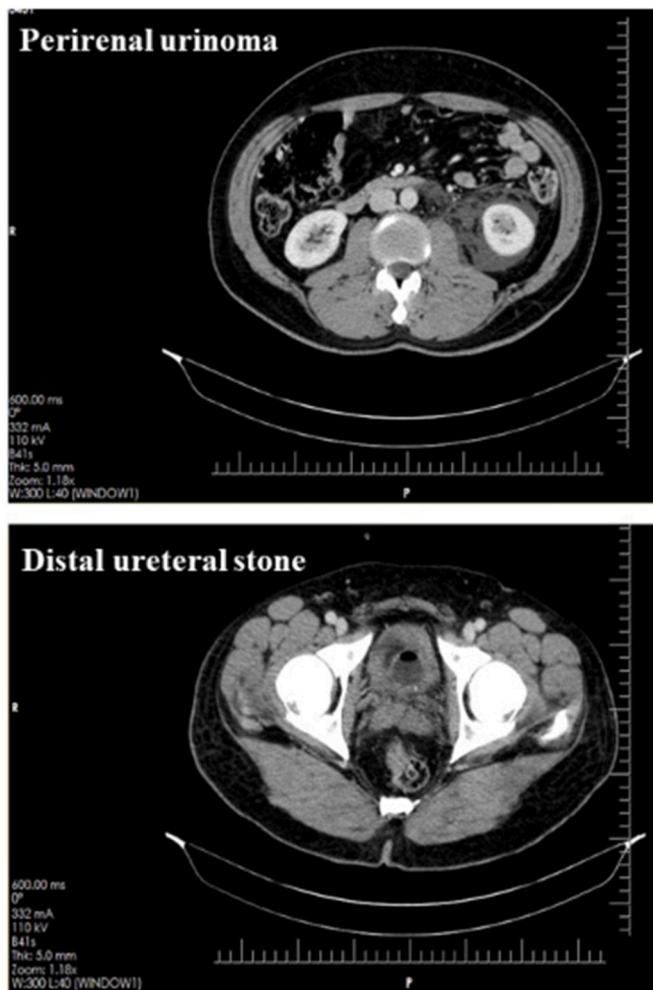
Abdominopelvic CT scan.
